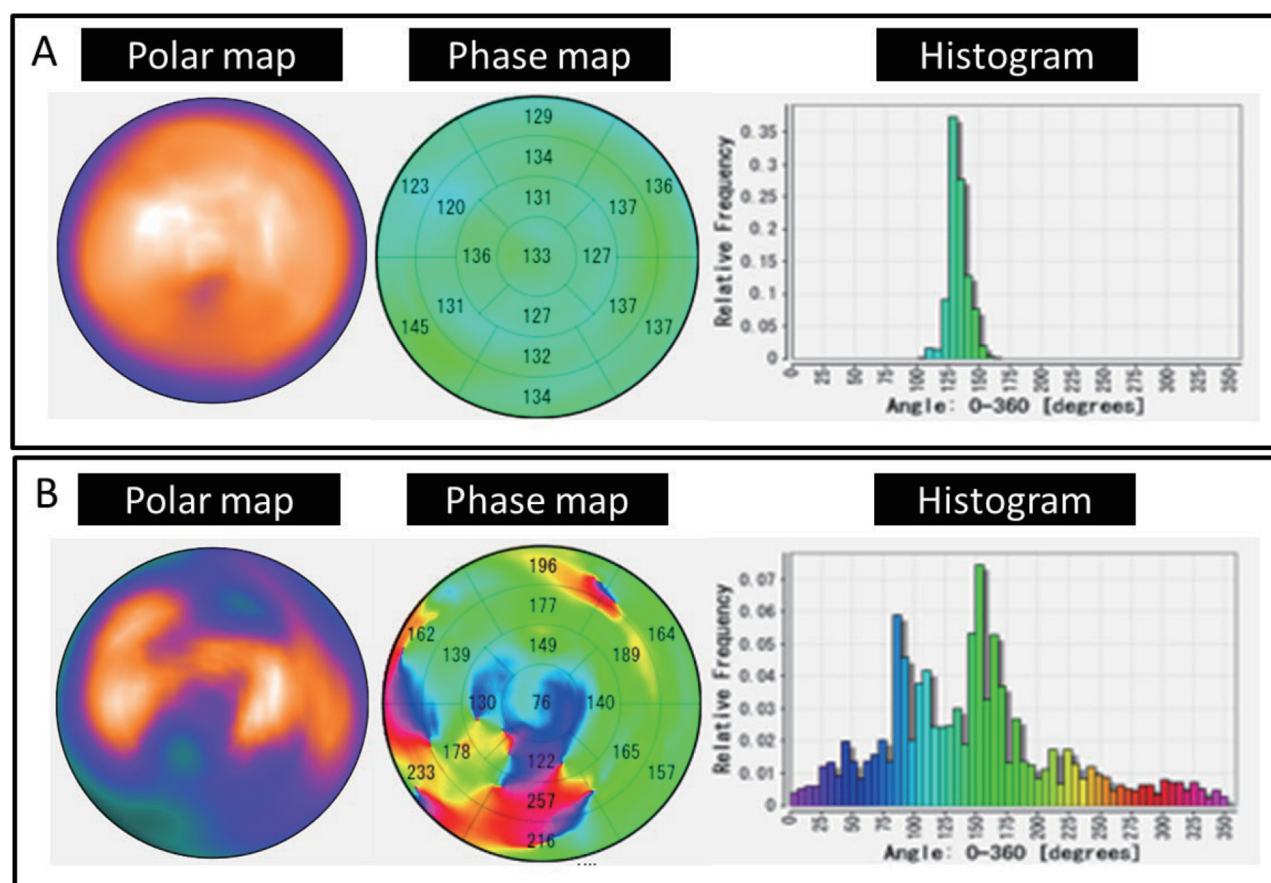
Phase analysis using SPECT perfusion imaging. Fourier transform was applied for the time-activity curve to estimate the timing of LV systole as demonstrated by the histogram. Case A had normal perfusion and normal entropy=36 (%), phase SD=7 (°), and bandwidth=28 (°) estimated by the histogram. Case B was a patient with severe multiple perfusion defects and high dispersion of the histogram of the phase analysis with high bandwidth: entropy=78 (%), phase SD=81 (°), bandwidth=327 (°).
